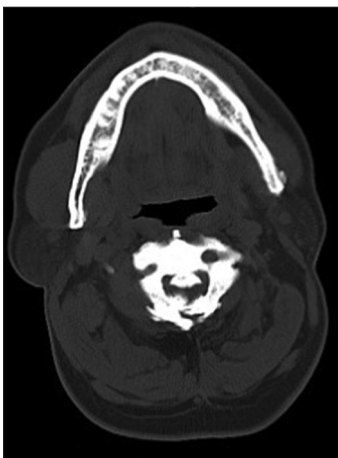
Recent CT scan cervical spine reveals- Post op defect of laminectomy with recurrence of spinal canal narrowing due to thickening/ossification of ligamentum flavum and thickening/ossification of posterior longitudinal ligament at C2 vertebral level
